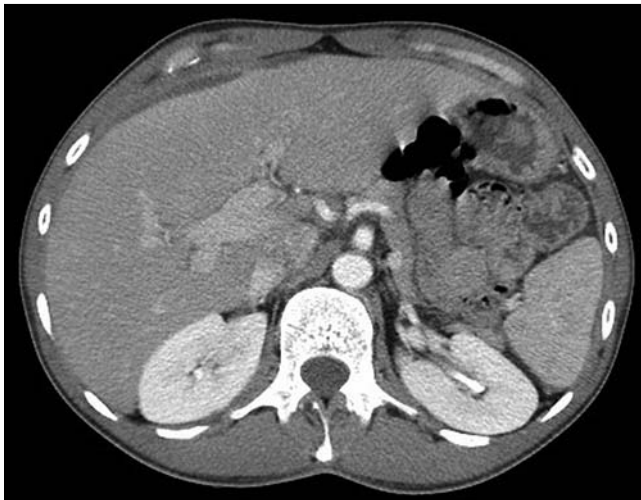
CT scan: fluid in the perihepatic space in a 45-year-old man with Fitz-Hugh–Curtis syndrome.
